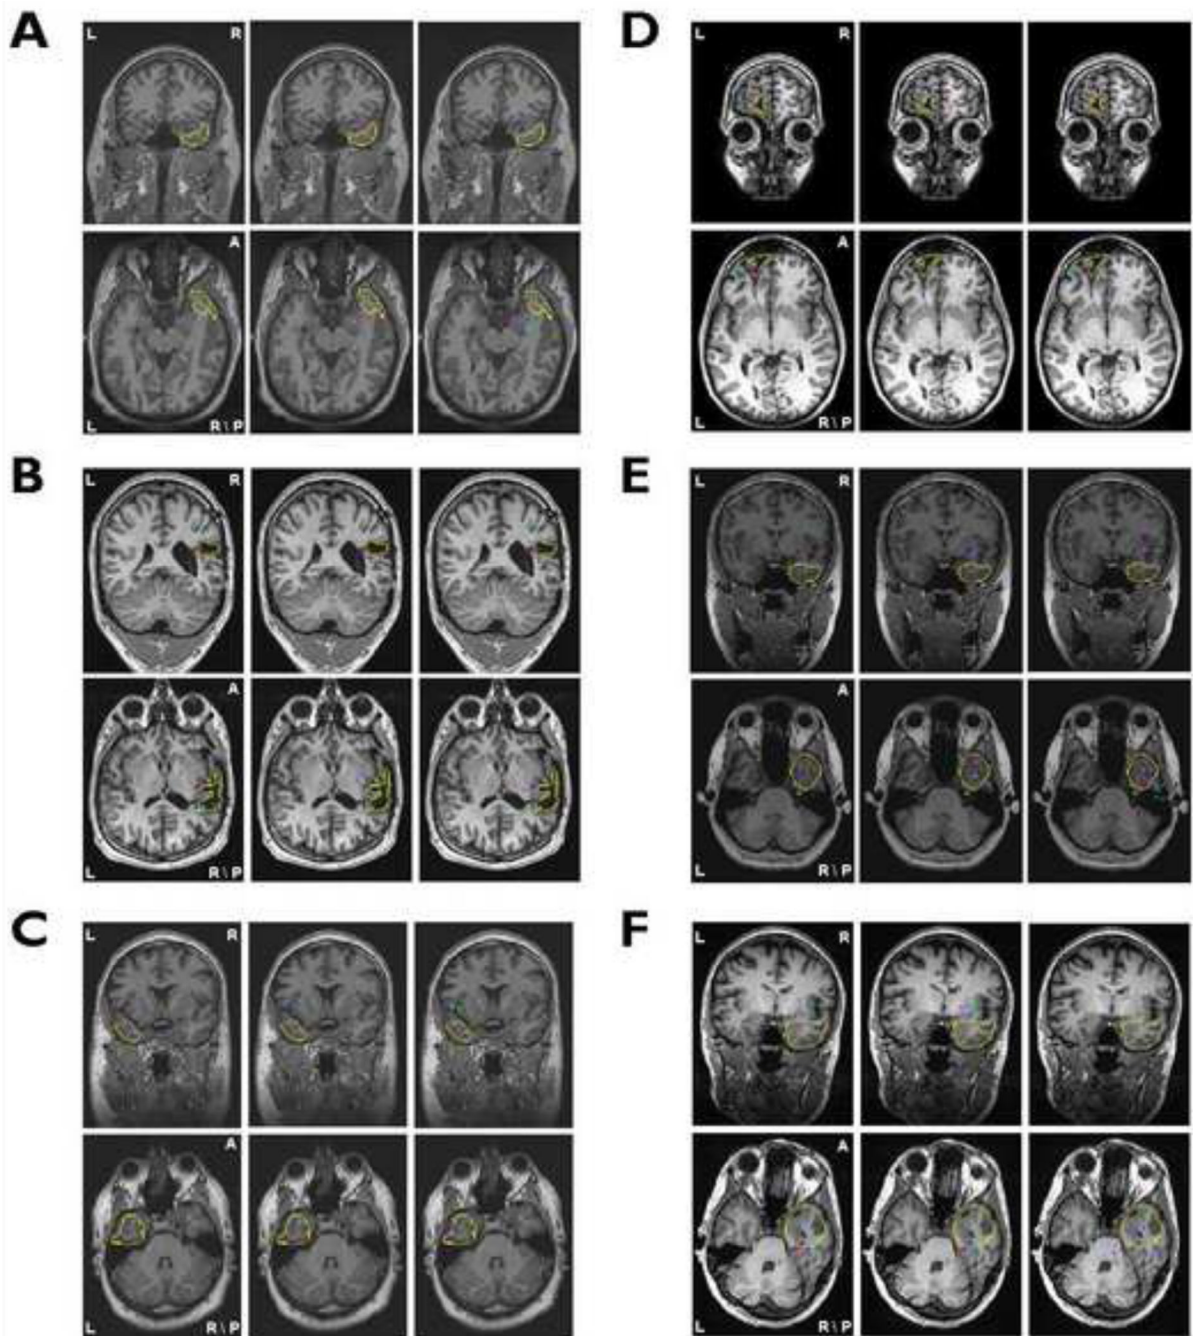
The source localization results projected on corresponding preoperative MR images for Patient 2 (A) through Patient 7(F). The layout of the results for each patient is the same as shown in Fig. 2.
